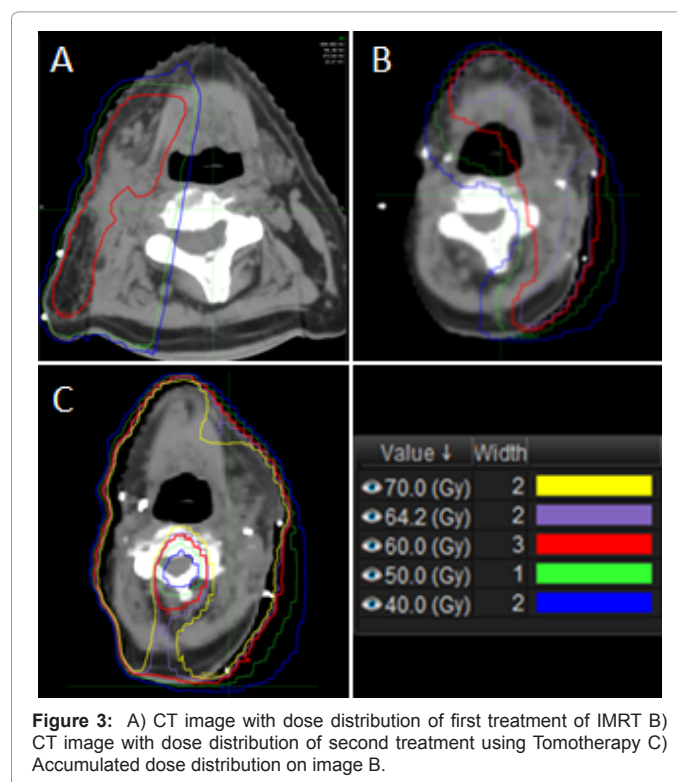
A) CT image with dose distribution of first treatment of IMRT B) CT image with dose distribution of second treatment using Tomotherapy C) Accumulated dose distribution on image B.
